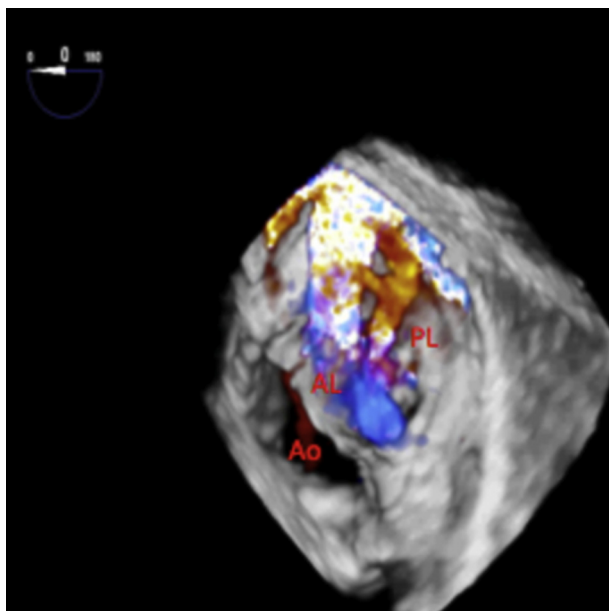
3D color doppler displayed spatial orientation and magnitudes of mitral regurgitation jets. Jet through perforation is severe.
